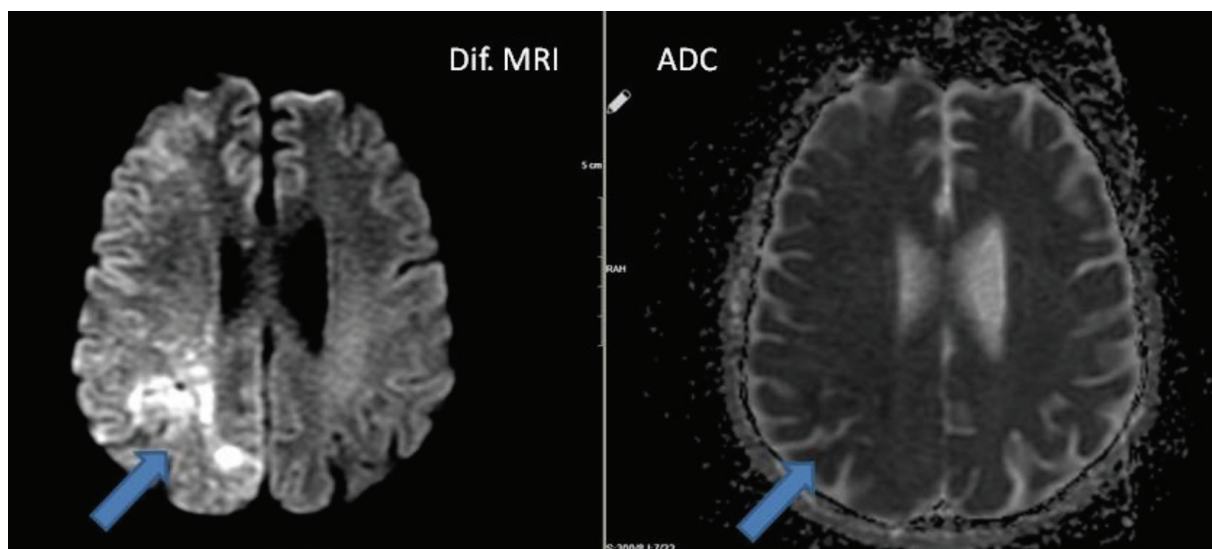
Arrows show acute cerebral infarct on the right cerebral hemisphere in magnetic resonance imaging
